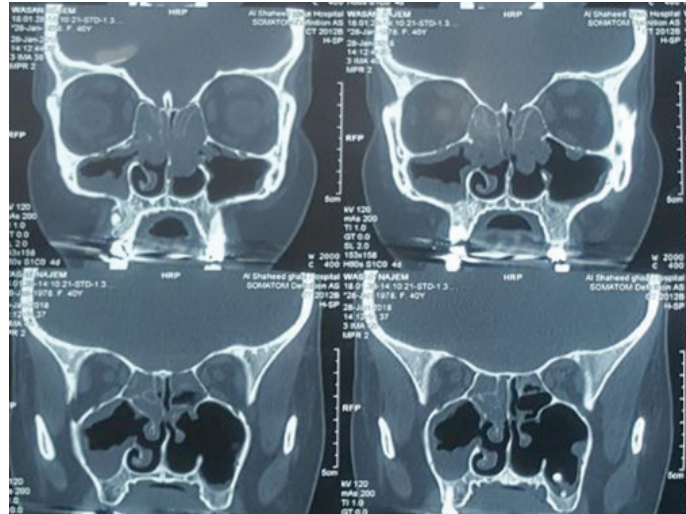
CT-scan coronal sections of patient with recurrent nasal polyps after FESS
